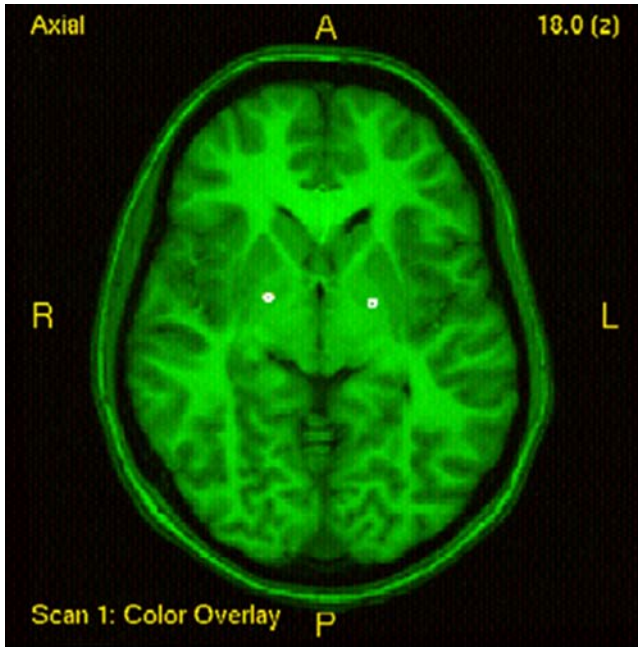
Fused axial CT and MRI scans following insertion of DBS leads. Stimulator electrodes traversing the GPi are displayed. (For color version of this figure, the reader is referred to the web version of this book.).
